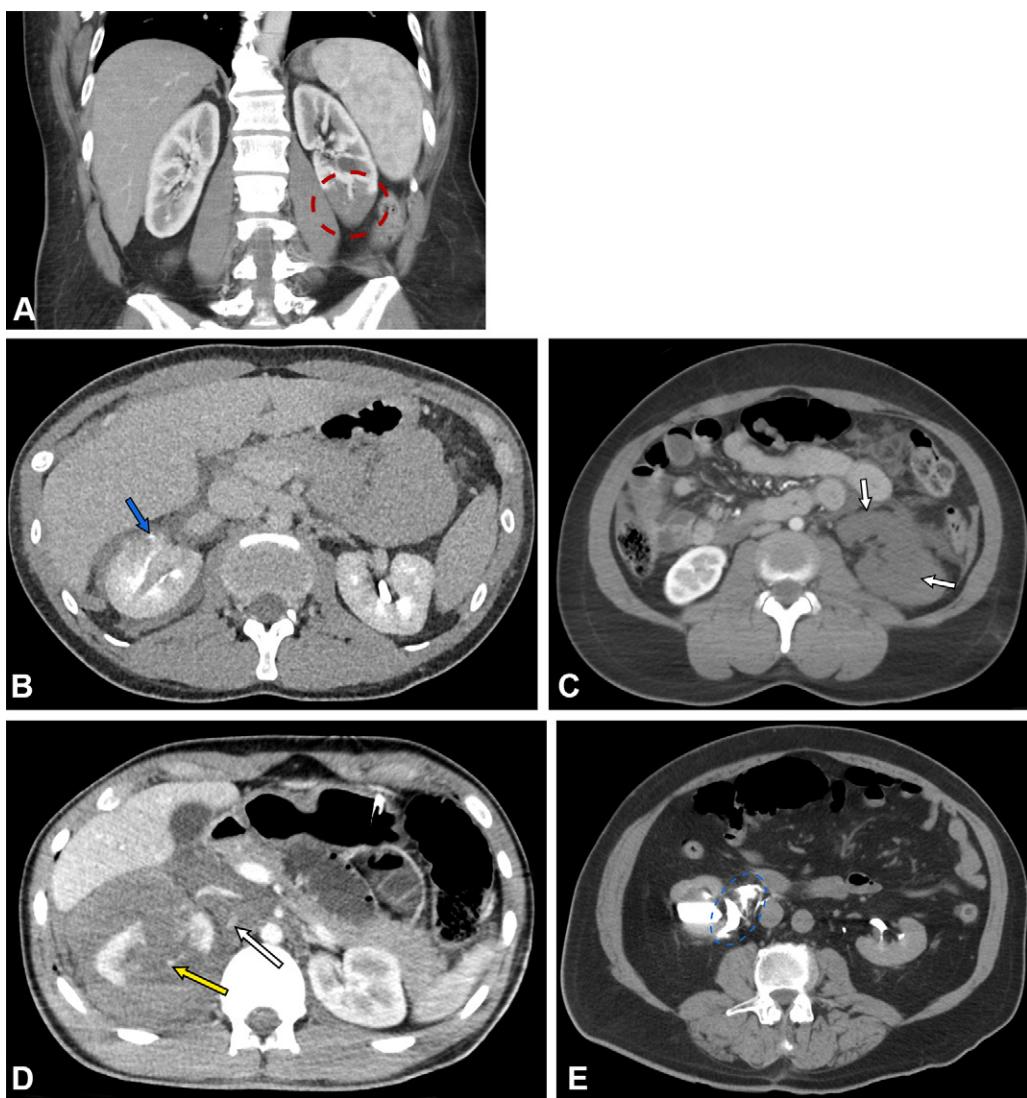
Grade IV renal injuries according to the revised 2018 AAST-OIS. (A) Coronal contrast-enhanced CT image in a 31-year-old man after a motor vehicle collision shows a left lower pole renal infarction (red oval), suggesting segmental vascular injury. According to the revised 2018 AAST-OIS, segmental vascular compromise and infarction and/or infarction as a sequela of vascular thrombosis are now classified under grade IV injuries. (B) Axial delayed phase contrast-enhanced CT image in a 26-year-old man after a car-versus-pedestrian collision shows a laceration of the right kidney extending from the anterior aspect, through the renal pelvis, and to the posteromedial aspect with contrast material extending beyond the collecting system (arrow), consistent with urine leak. No contrast material extravasation was noted during the arterial or portal venous phase to suggest active bleeding. The patient was managed conservatively with a good outcome. According to the revised 2018 AAST-OIS, renal pelvis laceration and complete ureteropelvic disruption are now included under grade IV injuries. An axial cine clip of this patient is shown in Movie 14. (C) Axial contrast-enhanced CT image in a 45-year-old woman after a motor vehicle collision shows complete left kidney infarction (arrows) with no evidence of active bleeding. The patient also suffered multiple other injuries (not shown), including a shattered spleen, liver laceration, pancreatic transection, and fractures of the transverse processes of the L1 and L4 vertebrae. The patient underwent multiple surgeries for the remaining injuries, but the kidney injury was managed conservatively. However, long-term follow-up revealed no functional recovery of the left kidney. (D) Axial contrast-enhanced CT image in a 16-year-old boy after a tree branch fell on him shows multiple severe right kidney lacerations, a large amount of blood extending beyond the Gerota fascia, and contrast material extravasation suggestive of active bleeding both within (yellow arrow) and beyond (white arrow) the Gerota fascia into the retroperitoneum. (E) Axial delayed phase contrast-enhanced CT image in a 71-year-old man after a fall shows contrast material extending into the right perinephric space (blue oval) and down to the right retroperitoneum, with no contrast material in the distal right ureter (not shown), diagnostic of a complete ureteropelvic disruption. The patient was managed with ureteral stent placement with a good response. An axial cine clip of this patient is shown in Movie 15.
